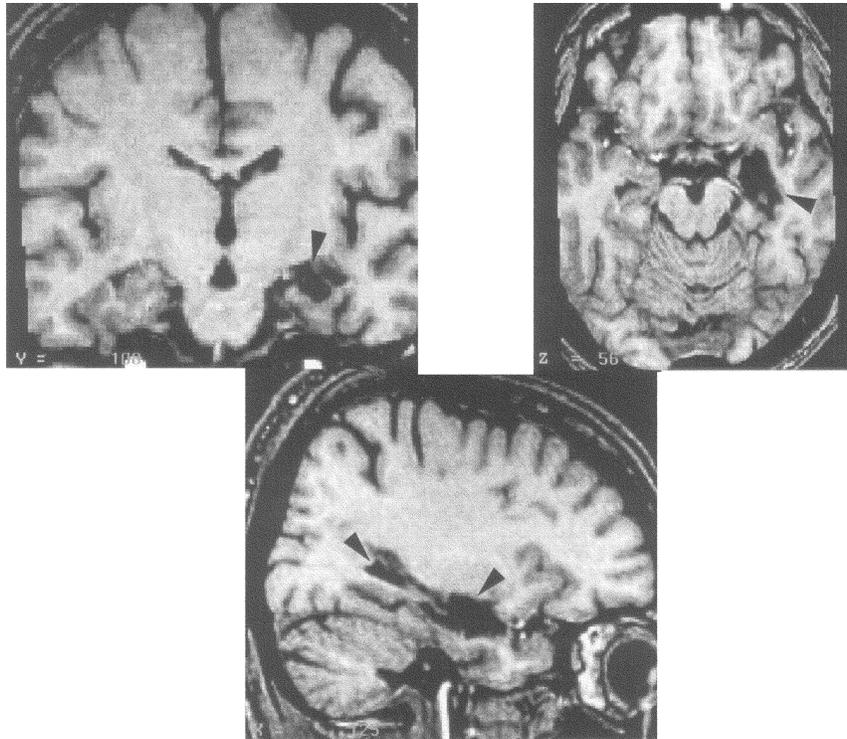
Thermal lesion to the right hippocampus. MRI sections in coronal, horizontal, and sagittal planes of a brain transformed into Talairach⁴² standard stereotaxic space. *Arrows* point to the lesion in the right hippocampus sparing the parahippocampal cortex.
